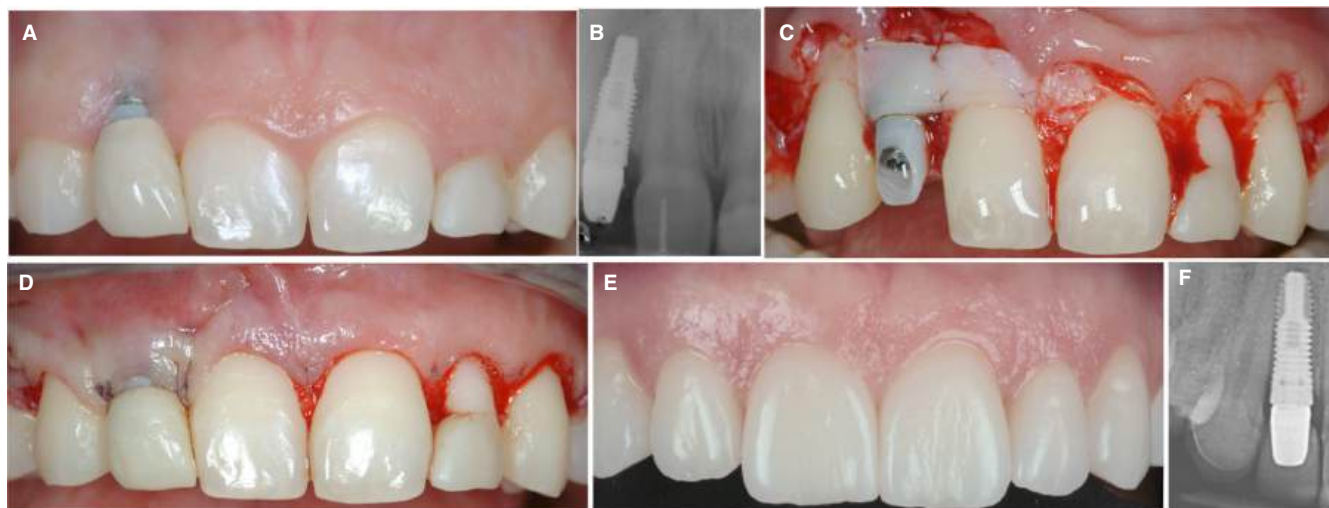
Soft tissue dehiscence associated with altered passive eruption. A, Clinical picture showing the soft tissue dehiscence at implant level and the altered passive eruption at teeth level. B, Intra-oral x-ray with a gutta-percha cone measuring the entity of the passive eruption. C, Connective tissue graft sutured and intrasurgical osseous remodeling. D, Flap closure showing the different position of the gingival margin: coronally placed at the implant site and apically positioned at the teeth level. E and F, Clinical and radiographic results
